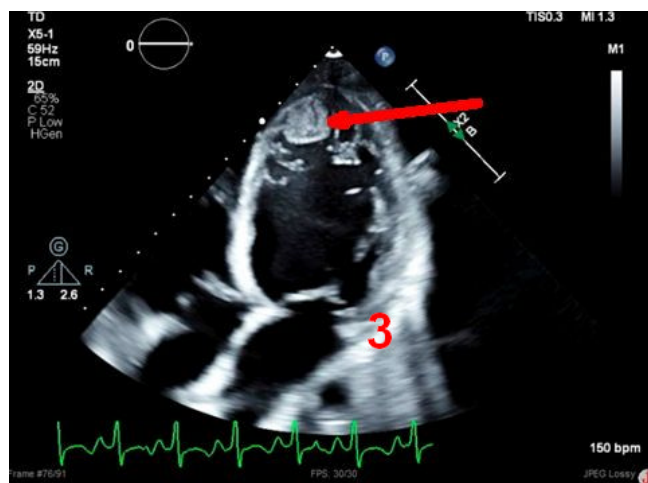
Apical four chamber view of Echocardiogram showing thrombus in the left ventricle measures 2.1cm x 1.7cm (red arrow).
